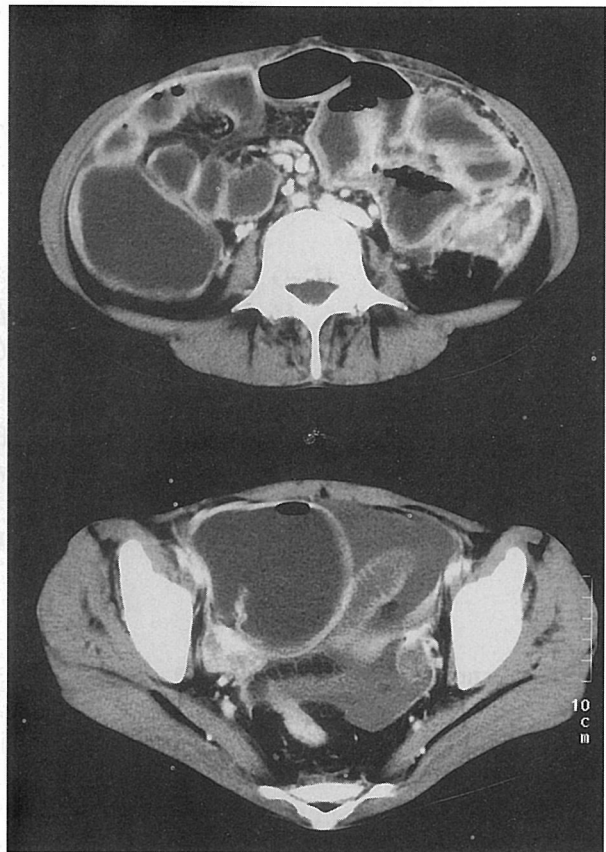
Abdominal CT reveals ascites standing in the abdominal cavity. Fluid collection and enhanced effect are apparent on inflamed tissue around the descending colon.
